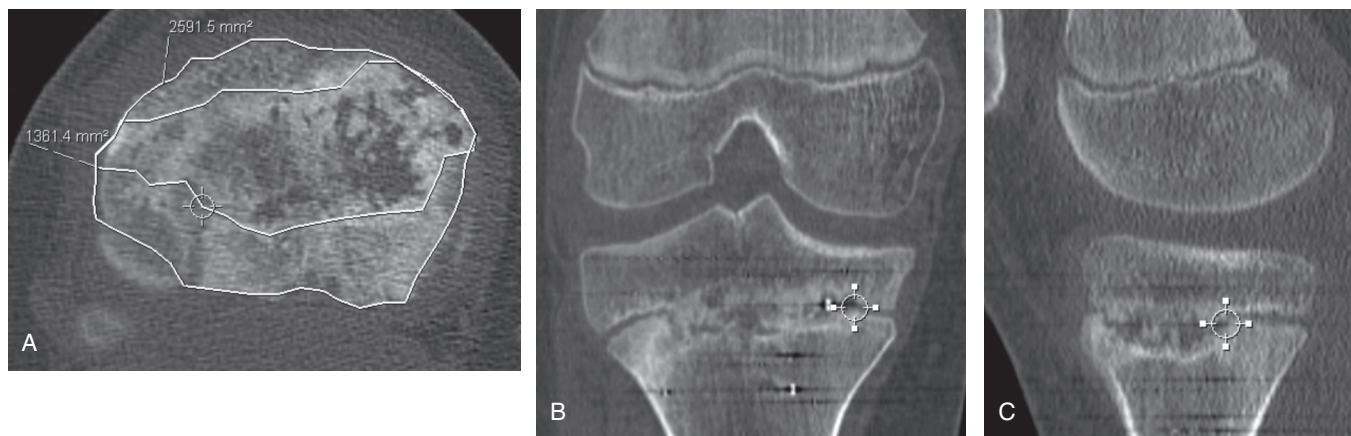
CT-scan reconstructions 3 months after tibial physodesis in a 12-year-old boy (right leg). A. CT axial reconstruction. B. CT coronal reconstruction. C. CT sagittal reconstruction.
